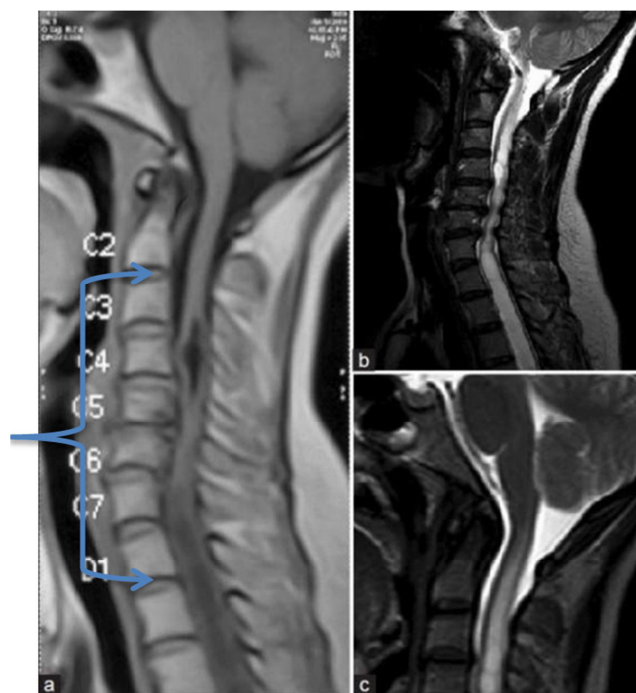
MRI findings in a 53 years old housewife with cervical spondylosis (Adapted from Venkata et al: Cervical spondylosis and syringomyelia. *J Neurosci Rural Pract*, 2014 [17]. Reprinted with permission).
